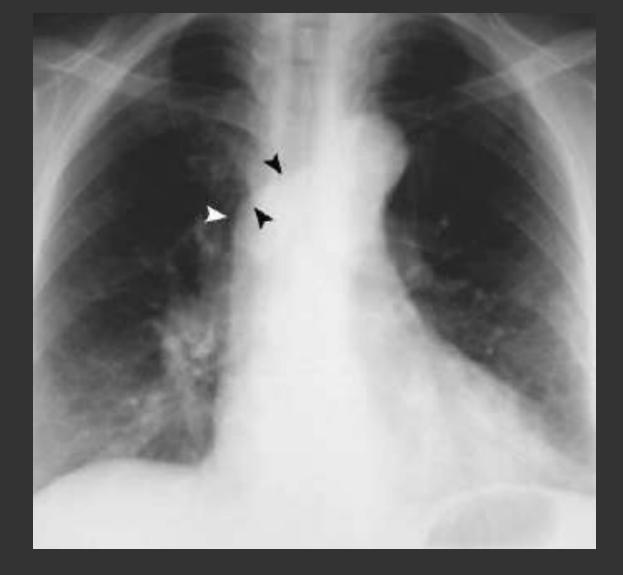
Anomalous origin of the Lt. P.A. in a 60 y old asymptomatic woman. (a) Chest radiograph shows an anomalous Rt paratracheal border (arrowheads).
